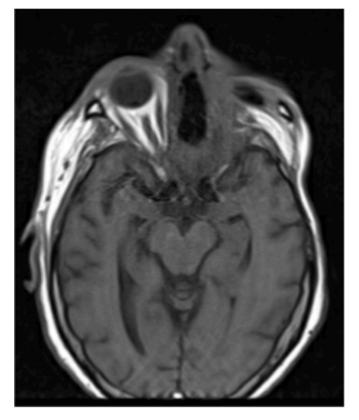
MRI Face with and without Contrast: Imaging approximately 7 months post left orbital exenteration, tumor resection, bilateral neck dissection with reconstruction, and radiation therapy. Extensive postsurgical changes are noted with plaque-like enhancement involving the floor of the anterior cranial fossa that extends into the interhemispheric fissure that may reflect scarring or residual malignancy.
